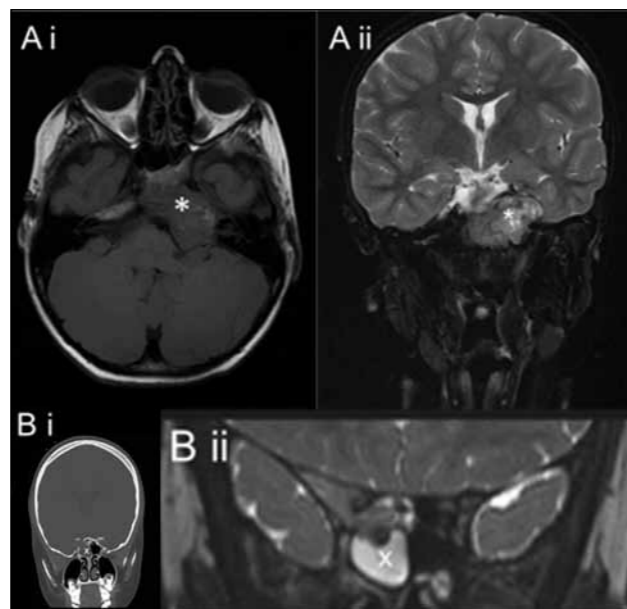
A) Axial T1 (i) and coronal T2 (ii) MRI showing an extensive Ewing's sarcoma recurrence of the clivus and petrous temporal bone (*). This was successful biopsied via a transnasal endoscopic approach and the child discharged home the following day. B) Coronal CT (i) and T1 MRI (ii) demonstrating a right orbital apex lesion (x) with marked bony destruction. The MRI shows the lesion extending from lateral to medial passing inferior to the optic nerve. Biopsy was performed using an endoscopic transnasal approach to reveal Langerhan cell histiocytosis.
